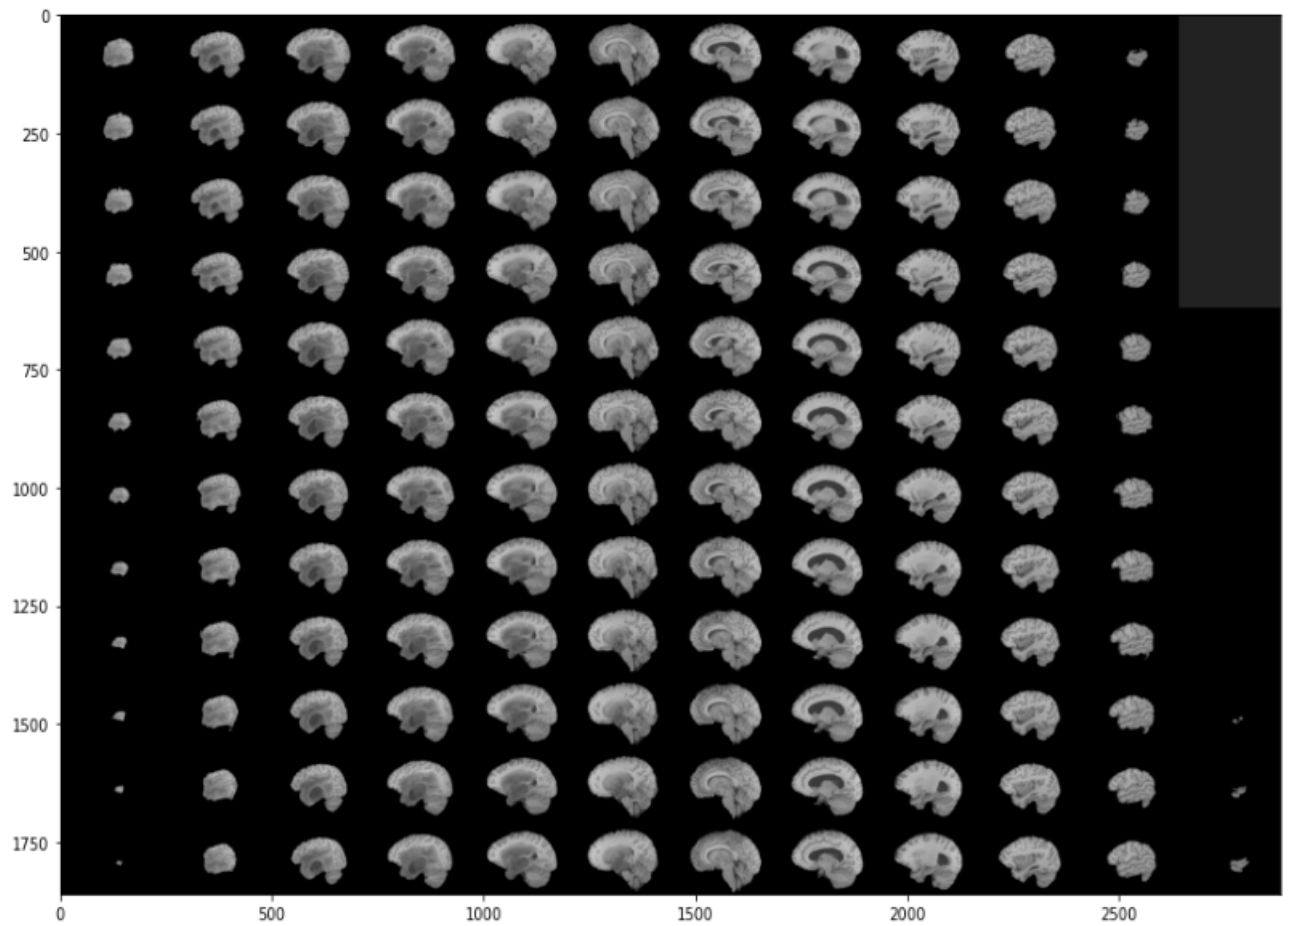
Each slice of MRI image from 3d data
